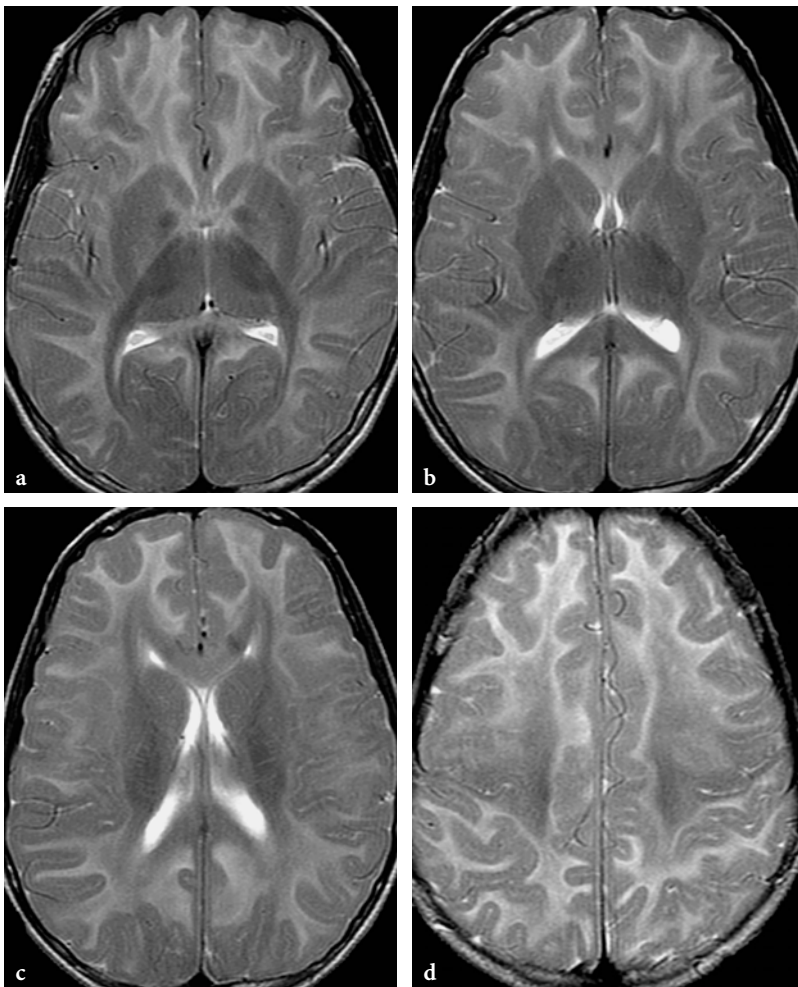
MR imaging findings in homocystinuria (cystathionine β -synthetase deficiency) in a female patient. Initial MR imaging study at the age of 8 years was essentially normal (not shown); after that examination, the patient dropped out from the metabolic clinic. a-d Follow-up study 4 years later, when the patient showed up again in a severely crippled status. Axial T2-weighted fast spin-echo images. Extensive demyelination is seen within the cerebral hemispheres (brainstem and cerebellum are normal, not shown here). The most severely involved structures are the subcortical U-fibers. Conversely, corpus callosum, internal capsules, pyramidal tracts, and optic radiations are relatively spared. Subtle signal abnormalities are also seen within the caudate nuclei, putamina, and even thalami, although the ventrolateral nuclei are spared. Overall, the pattern of residual myelinated structures is reminiscent of the early postnatal myelination status, characterizing a retrograde demyelination process
